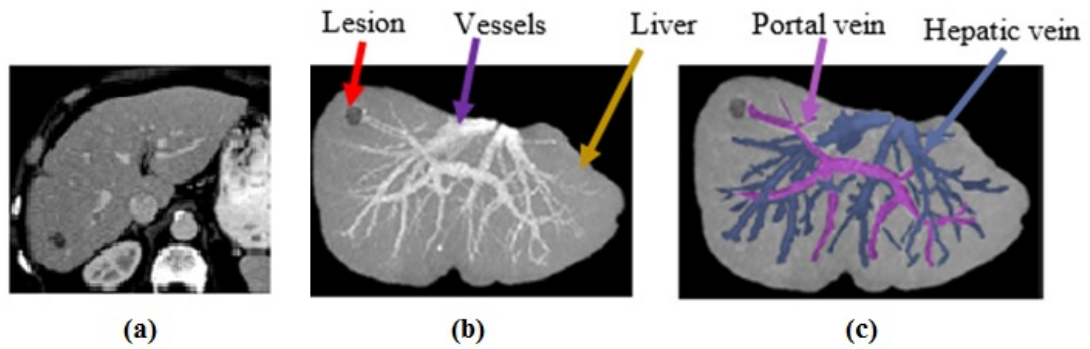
3D Liver vessels construction and classification; (a) 2D CT scan image; (b) 3D volume rendering of liver with vessels and lesion; (c) 3D vessels classification, magenta is portal vein and blue is hepatic vein.
